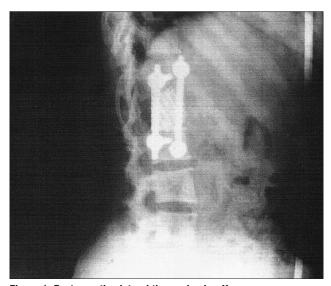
Postoperative lateral thoracolumbar X-ray
